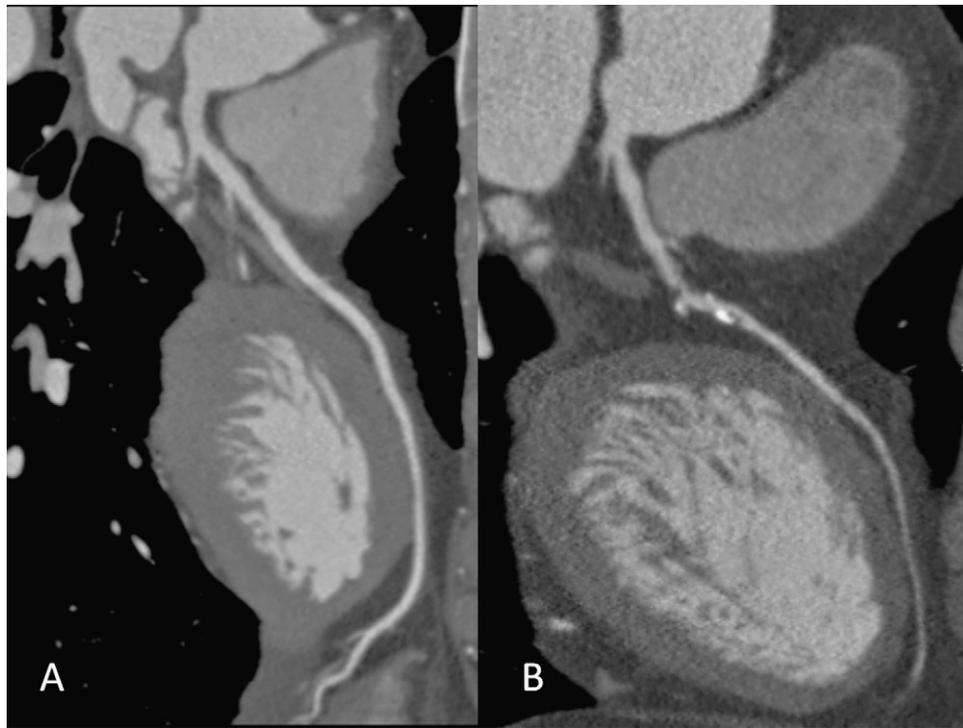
Left main and left anterior descending coronary arteries of two participants representing: (A) normal coronary computed tomography angiography (CTA) and (B) non-calcified and calcified coronary plaques identified by CTA.
